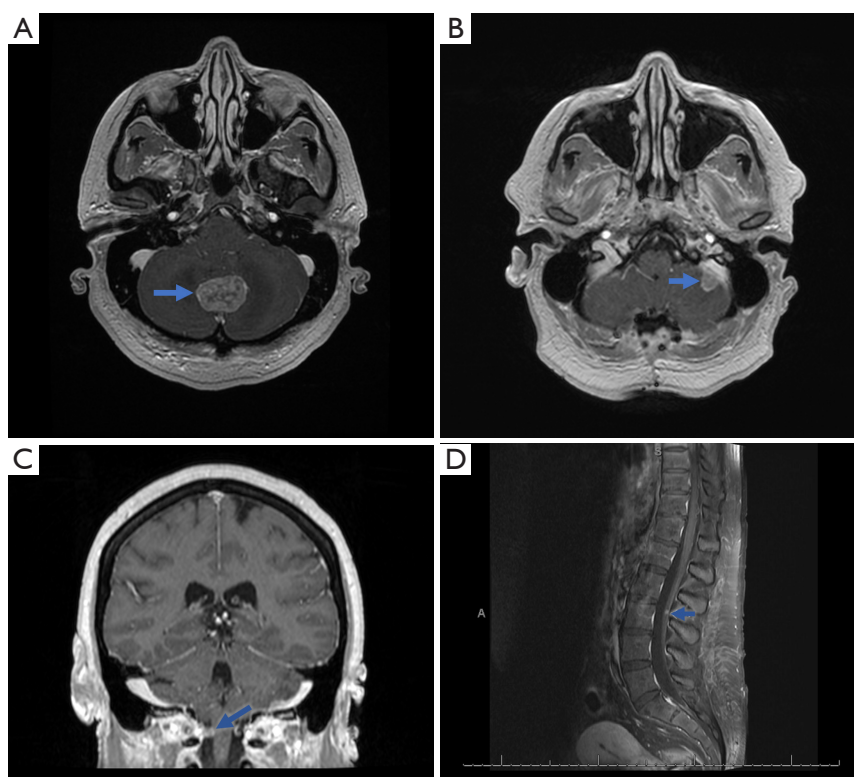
Central nervous system metastases detected on imaging in case 1. (A) MRI of vermian lesion (T1) (blue arrow denotes lesion). (B) MRI of dural-based lesion over left cerebellum (T1) (blue arrow denotes lesion). (C) MRI of dural-based lesion by foramen magnum (T1) (blue arrow denotes lesion). (D) MRI of dural-based lesion by cauda equina nerve roots (T1) (blue arrow denotes lesion). MRI, magnetic resonance imaging.
